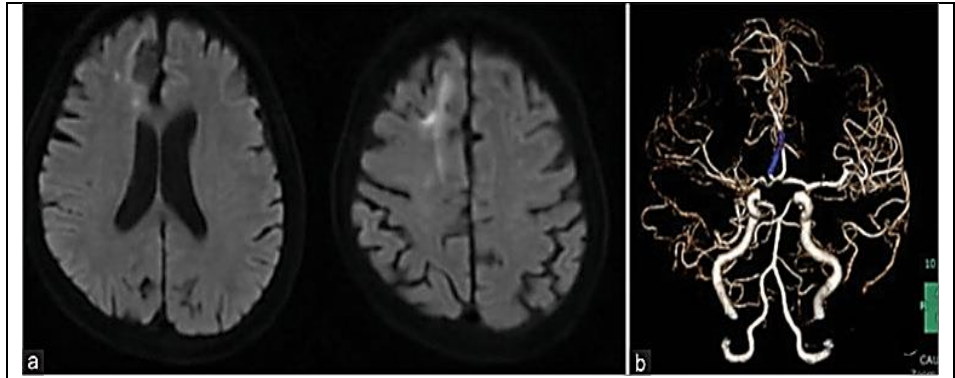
(a) Diffusion-weighted imaging revealed no new infarctions. (b) CT angiography revealed recanalization of the right A2 segment.
